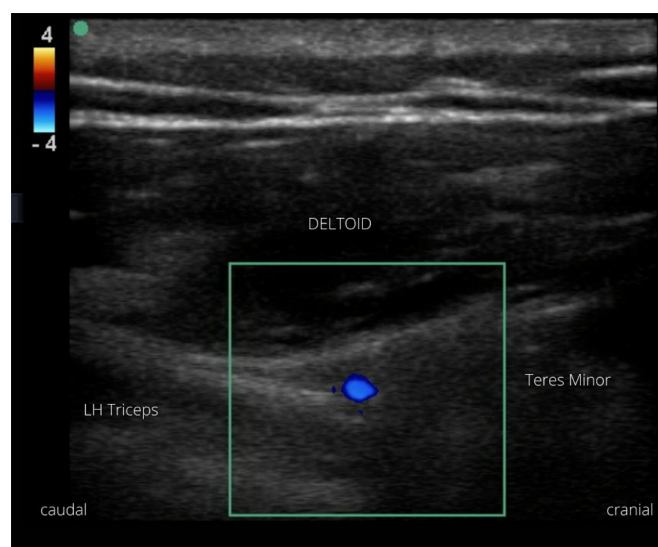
Ultrasound image of the quadrilateral space with doppler showing the posterior circumflex humeral artery.
